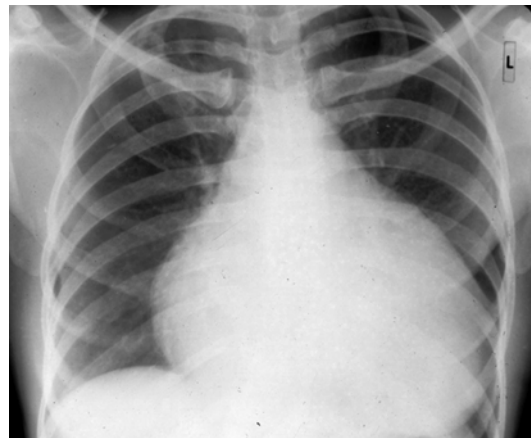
Enlarged ("water bottle") silhouette of the heart on chest radiograph in a patient with pericardial effusion
